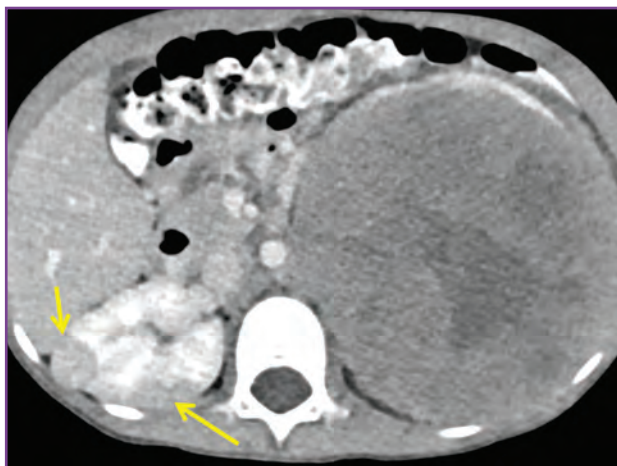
Axial computed tomography of the abdomen and pelvis performed with intravenous contrast material shows a large left renal mass and small right renal masses (arrows).
